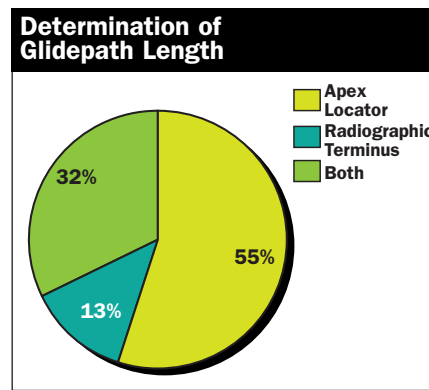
Determination of Glidepath Length. The apex locator, or a combination of apex locator and radiographic terminus, is the clinician’s choice. Canal length accuracy is excellent when both methods of length determination validate each other. The important thing to remember is that the length is dynamic and becomes shorter, especially in the early stages of rotary shaping, due to canal shortening.
